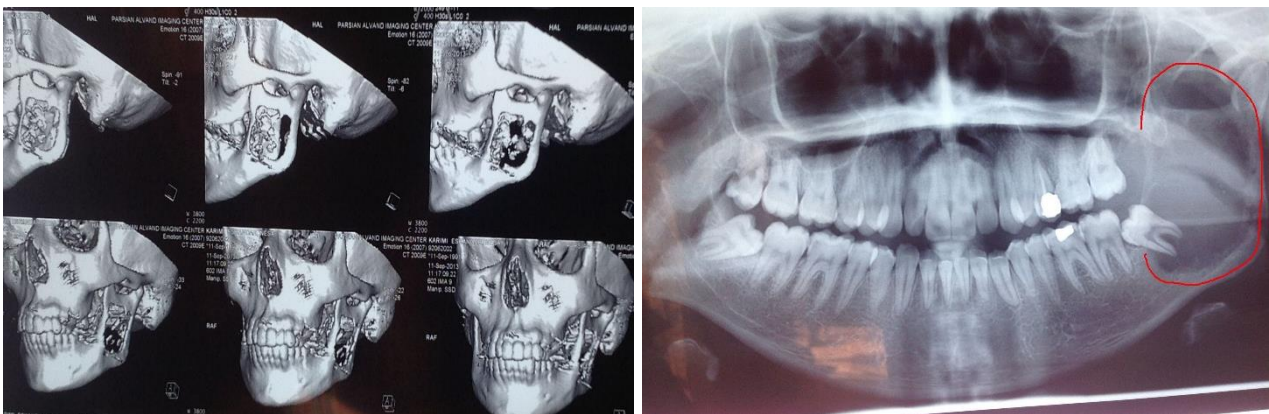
Panoramic radiograph and 3D images demonstrated a well- defined unilocular radiolucency with massive bone destruction and thinning of mandibular border
